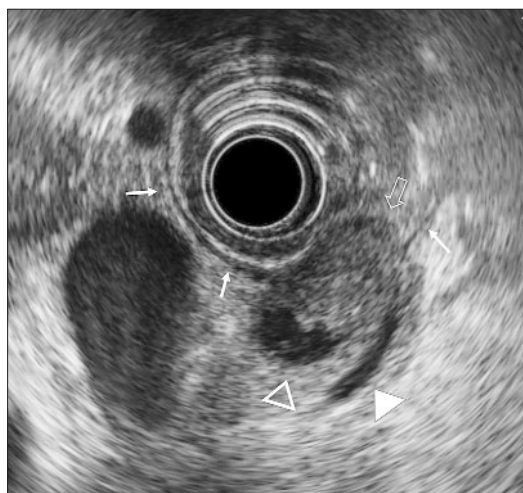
Endoscopic ultrasonography (EUS). EUS demonstrates a papillary structure extending from the papillary bile duct toward the bile duct. ↓ indicates papillary structure, ↓ indicates duodenal muscular layer, ▽ indicates bile duct, ▼ indicates main pancreatic duct.
